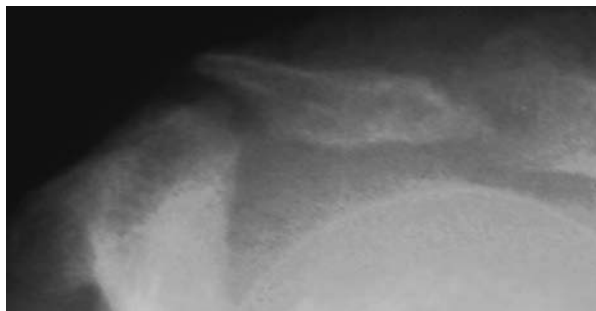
Outlet view radiograph depicting an acromial fracture postoperatively after shoulder arthroscopy and subacromial decompression.
